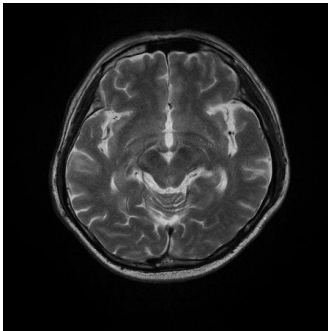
Axial 2D FLAIR slice image example
